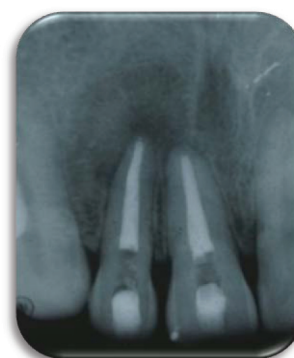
Postoperative radiograph (follow up after 9 months)
